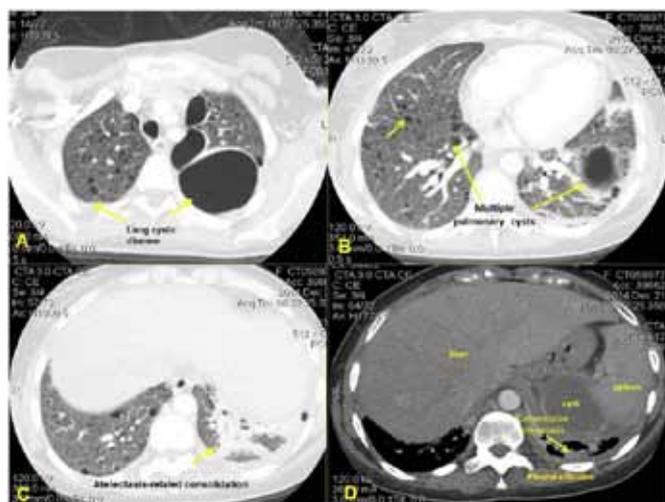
Computed tomography pulmonary angiography showing: (A) A severe lung cystic disease with three big lung cysts (arrows) in left upper lobe which destroyed lung parenchyma, (B) Multiple intrapulmonary smaller lung cysts bilaterally (arrows), (C) A compressive atelectasis-related consolidation in left lower lung lobe (arrow) and a subtle pleural effusion because of the displacement of the left-sided diaphragm, and (D) Lower slices of the imaging demonstrated a big subdiaphragmatic cystic formation pressing against left hemidiaphragm.
